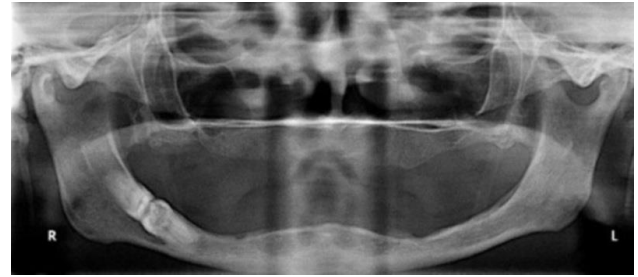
In edentulous patient, panoramic radiograph showing impacted right second and third mandible molars with occlusal surfaces contacting each other in a single follicular space.
